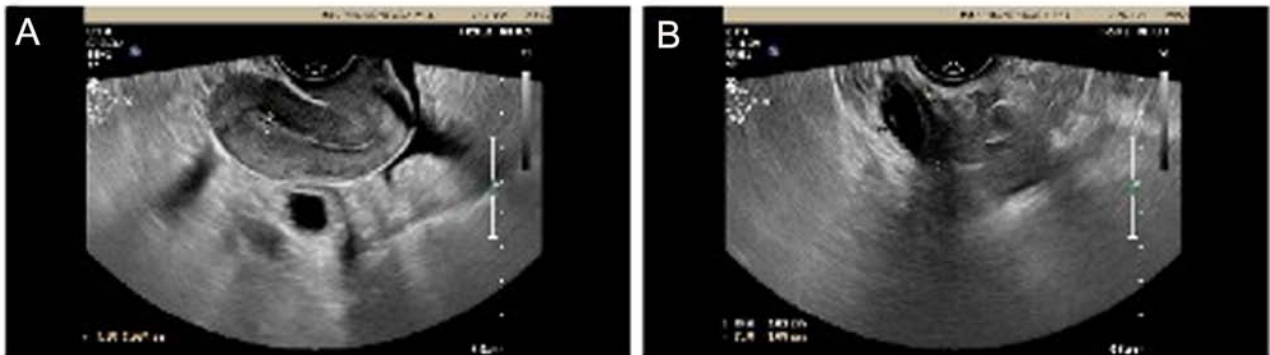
Normal ultrasonography of the pelvis after abortion. (A) No obvious echo found in the uterine cavity. (B) No obvious echo found in the ovary.
